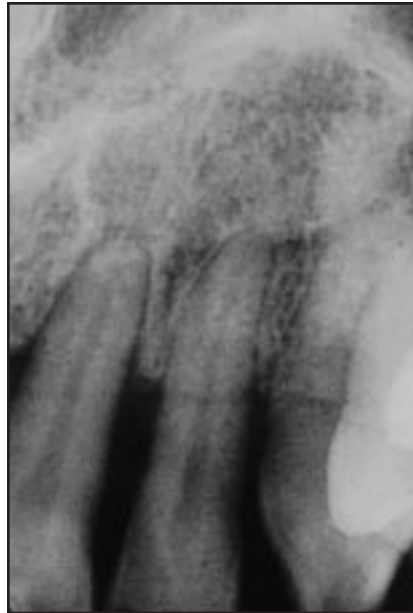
(right) Panoramic radiograph shows periodontal involvement of maxillary left central incisor.
